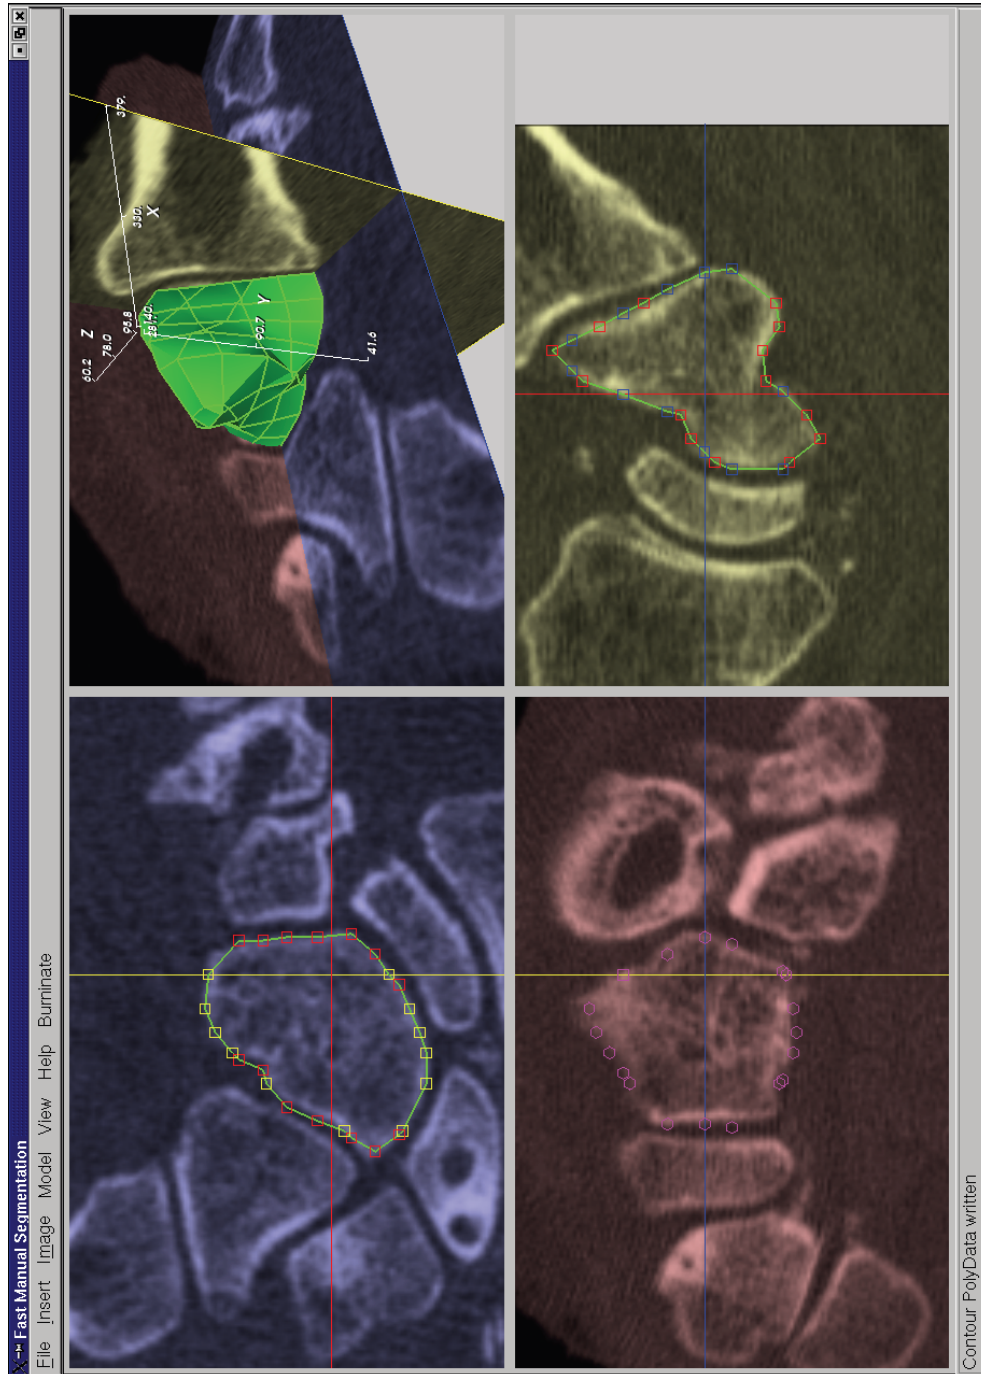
Screenshot of the segmentation application. A CT dataset of a human wrist and several contours are shown. The colour of the lines of the crosshair and the colour of each control point correspond to the colour of the intersecting orthogonal planes.
